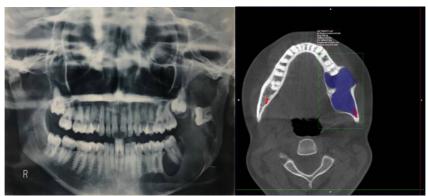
region of the sigmoid notch Figure 2 : CBCT- Axial section.
